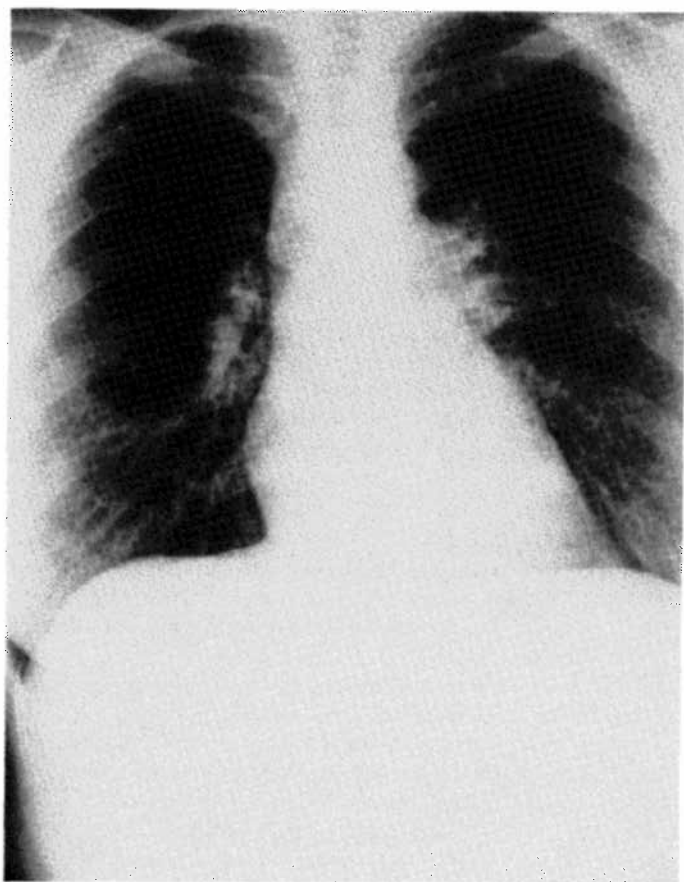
Left hilar adenopathy with possible right hilar adenopathy. Chest X-ray, 1990.
